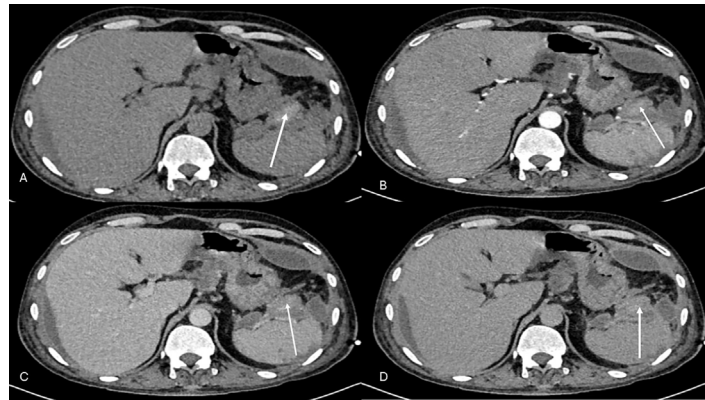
Case 2. CT scan of the abdomen at follow-up after 2 weeks of embolization. Contrast enhanced CT scan of the abdomen at the level corresponding to the pre-embolization scan with noncontrast (A), arterial (B), venous (C) and delayed [5 minutes postcontrast] phases. The site of the pseudoaneurysm appears hyperdense on noncontrast CT (white arrow in A). There is no contrast opacification of the pseudoaneurysm sac on subsequent multiphase acquisition (white arrows in B, C and D), thus confirming stable and persistent occlusion of the pseudoaneurysm sac.
